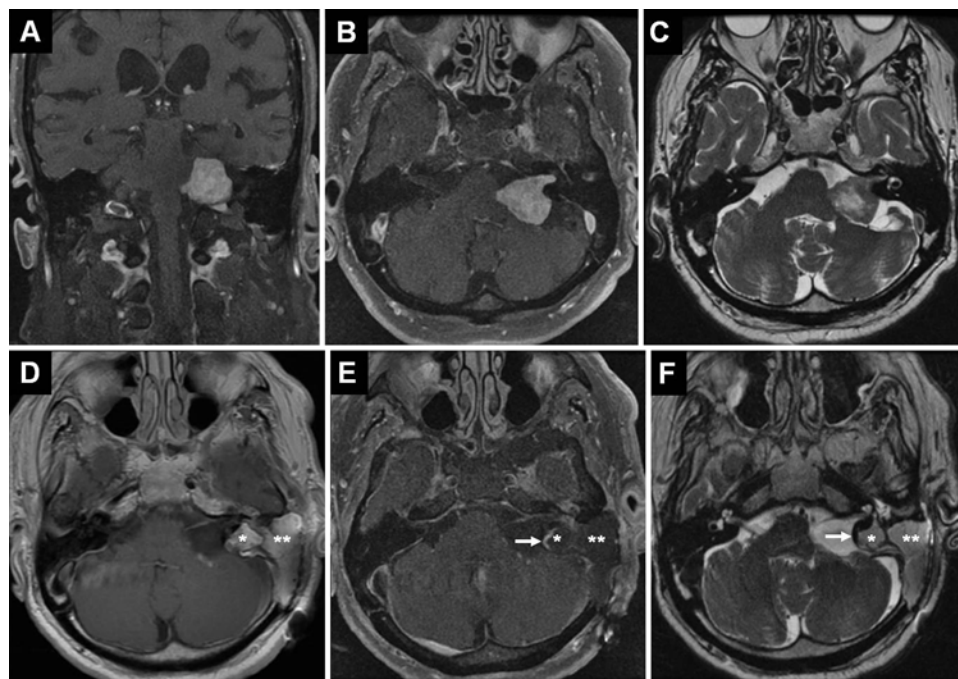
Preoperative (A–C) and postoperative (D–F) MR images. A–C: Coronal (A) and axial (B) T1-weighted images after Gd administration and an axial T2-weighted image (C) demonstrate a left-sided acoustic neuroma within the cerebellopontine angle with tumor extension into the fundus of the IAC. A left-sided translabyrinthine approach was performed followed by fascial sling reconstruction. D–F: Axial T1-weighted images with Gd administration (D) and fat suppression (E), and a T2-weighted image (F) demonstrate complete tumor removal with excellent decompression of brainstem. The fascial sling (arrow) allows suspension of the fat graft within the mastoid cavity. Note that the fat graft is not in any direct contact with or compression against the facial nerve, brainstem, and cerebellum. This technique also minimizes the volume of fat required for reconstruction. * deep fat layer;  superficial fat layer.
